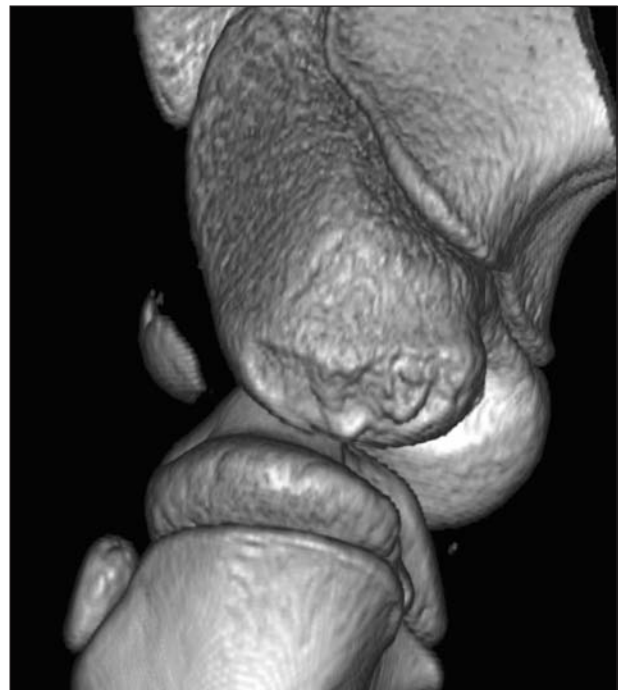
Three-dimensional volumetric image reconstruction of a CT scan of the right stifle joint, as viewed from a caudolateral and slightly distal perspective. Notice the extensive deformation of the medial femoral condyle.
